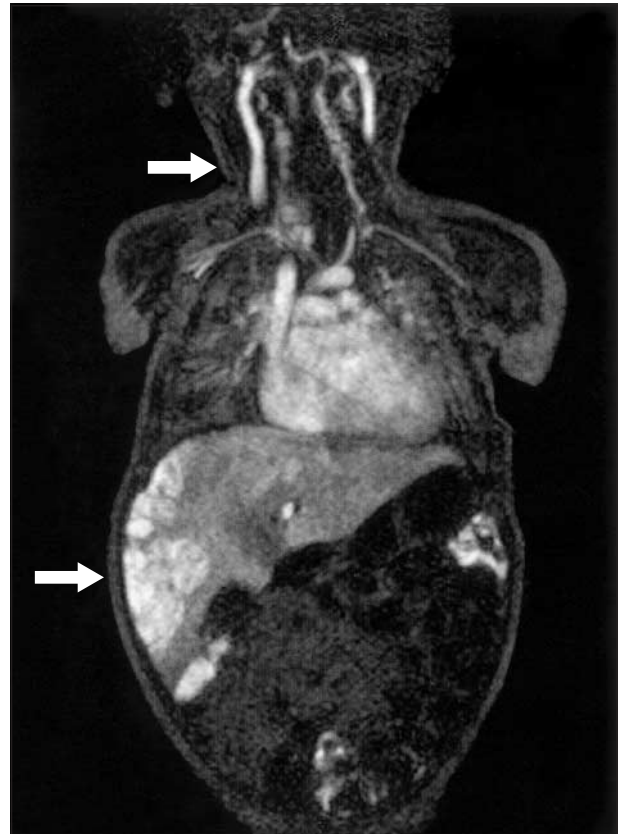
Magnetic resonance image revealing multiple hepatic and paratracheal hemangiomas (arrows) in patient 1.
